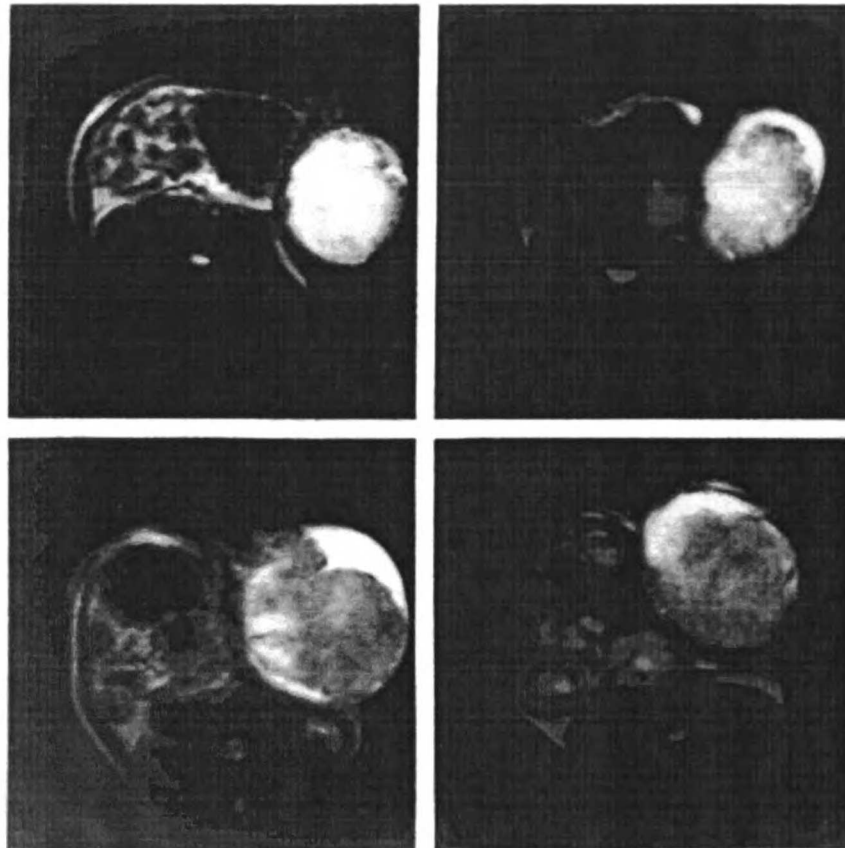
T2-weighted ^1H MR images of control (left) and androgen-deprived (right) tumors initially (top) and three weeks after orchiectomy (bottom). Imaging parameters were the same as for T2-weighted images in Fig. 1. Note the difference in tumor growth rate between the treated and untreated tumors, with no significant changes in tumor signal intensities.
